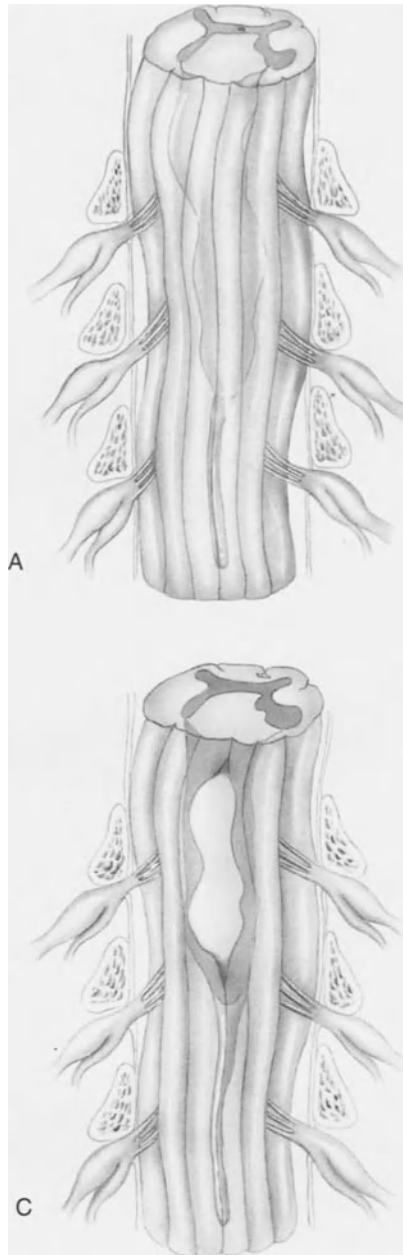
Ventral column astrocytomas are not nearly so common in our experience, maybe because before MRI we were not able to identify them. They distort the cord (A) as much as the dorsal or lateral column tumors, but if the surgeon approaches the tumor posteriorly he is not aware of these topographical changes. In (B) one has a visual explanation of why at surgery for even a relatively large intramedullary astrocytoma, the myelotomy, performed in the median longitudinal sulcus, may not bring the surgeon immediately upon the tumor: it is ventral in location. Exophytic components of medullary tumors (C), even astrocytomas, occur. In (D) the surgical approach was ventrolateral, and possible to plan only because of the horizontal MRI images.
